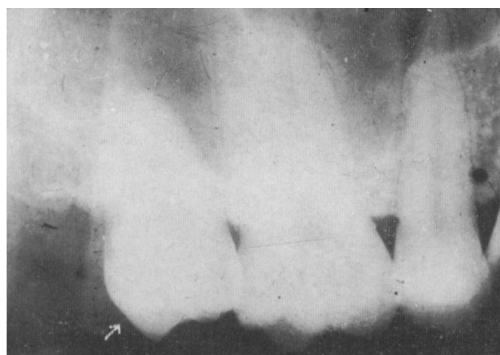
X-Ray of left upper maxilla.
